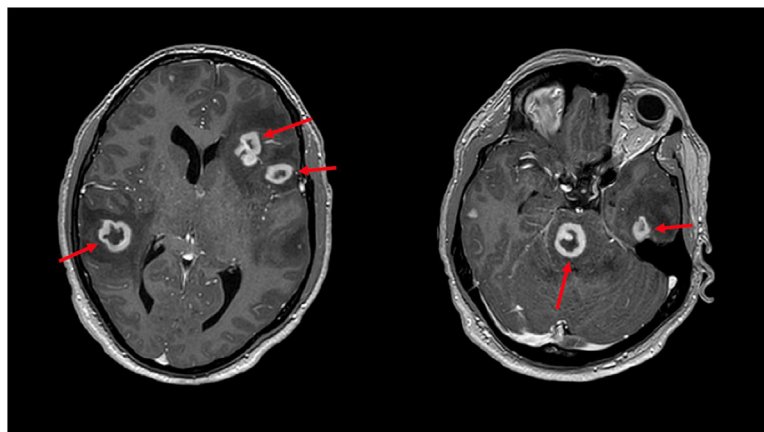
Axial sections of a T1 weighted post-gadolinium MRI of the brain reveal numerous intracranial lesions, demonstrating ring enhancement (red arrows).
